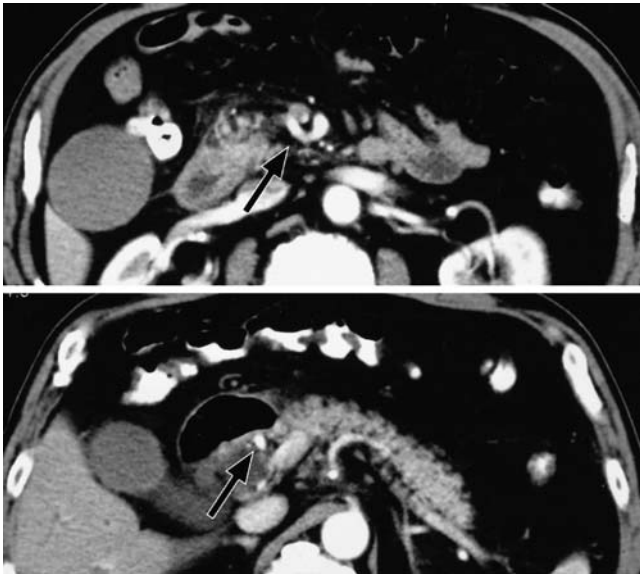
Computed tomography of the 65-year-old male subject described in this case report. The *arrow* shows the replaced common hepatic artery originating from the superior mesenteric artery coursing along the ventral side of the head of the pancreas and along the right side of the portal vein
